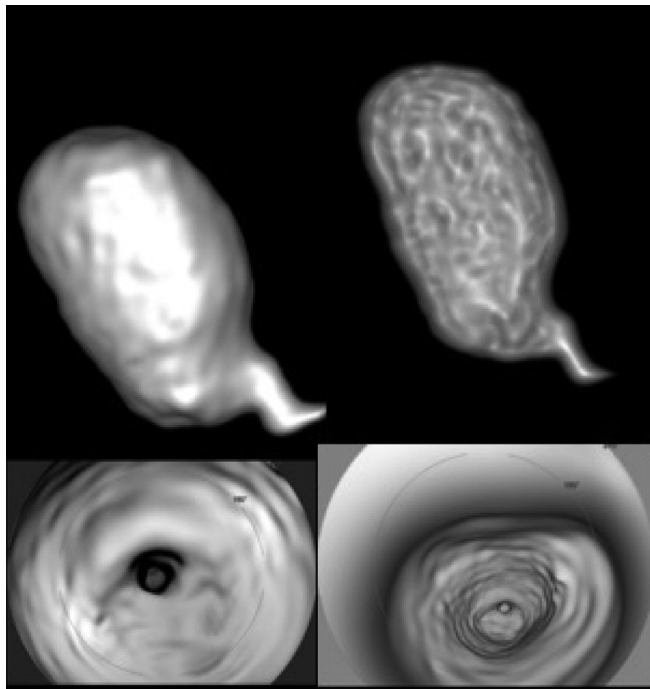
Virtual fetal cystoscopy using MRI showing a 3D reconstructed obstructed bladder with its trabeculation (upper images) and a cystoscopic-like view of urethra and bladder outlet obstruction(lower images). For more visual content check Video 1
